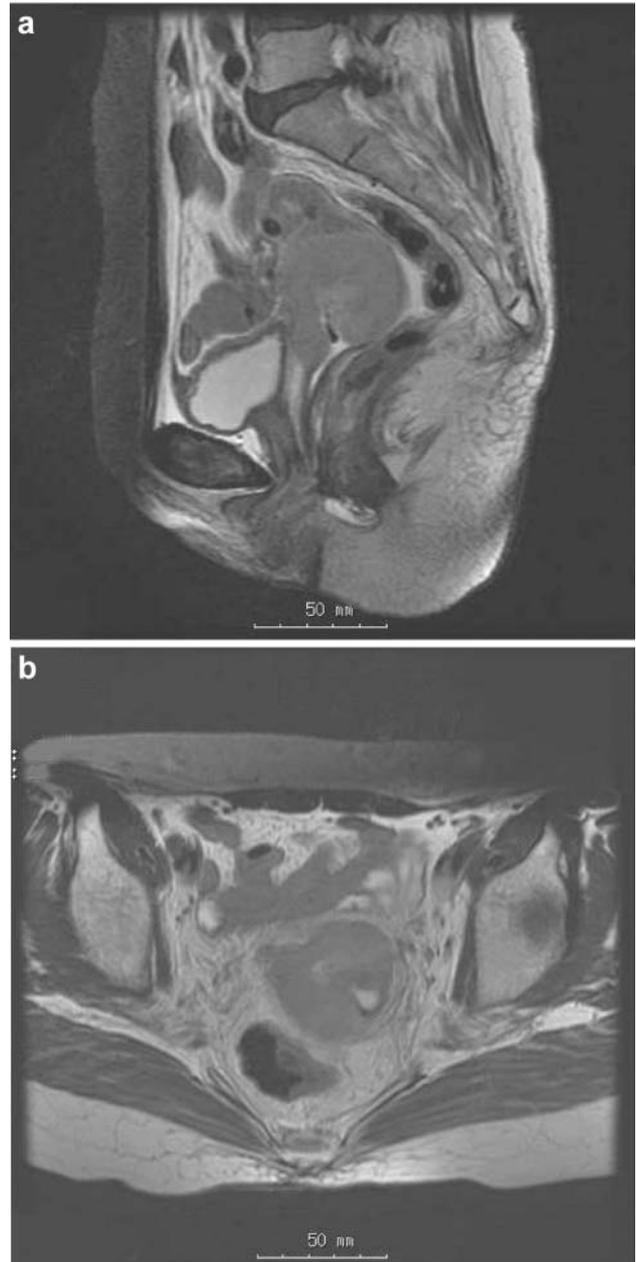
Magnetic resonance imaging of the pelvis before the initiation of radiation therapy. A bulky cervical tumor was detected. This is a sagittal image of T2WI (a). This is a axial image of T2WI (b).
